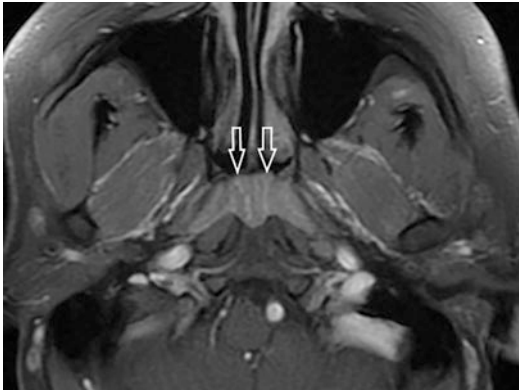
Normal adenoid tissue. Axial contrast-enhanced fat-suppressed T1-W MR image shows alternating dark and bright vertical stripes typical of adenoid tissue in the nasopharynx (open arrows)
